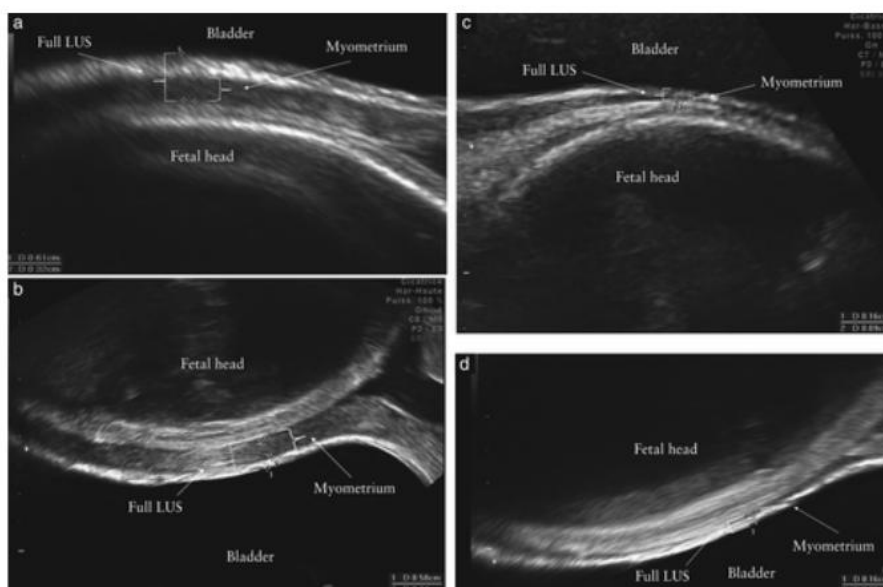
shows a thick and a thin LUS measured by transabdominal sonography.
